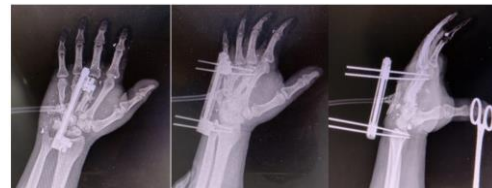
AP, oblique and lateral X-ray control of the 9.5 cm external fixator in the head of the 3rd metacarpal to the distal radius of the left hand.
